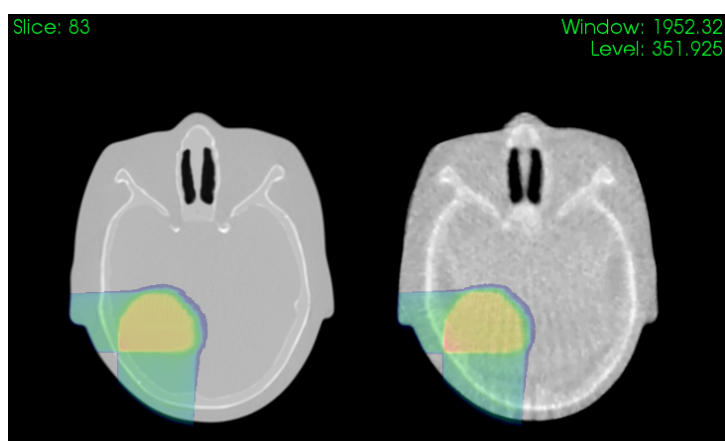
Proton radiography.*
